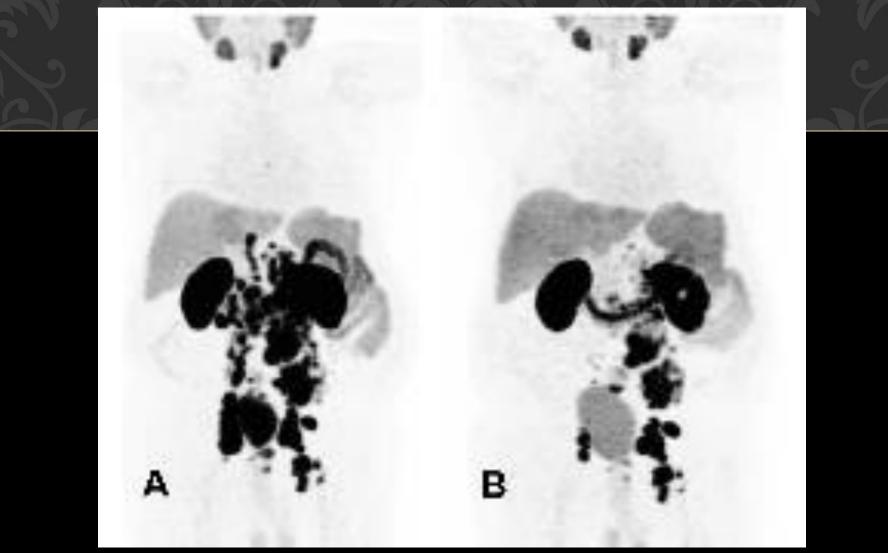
A 74-year old patient with hormone and chemo-refractory prostate cancer underwent PSMA PET/CT. (A) : which showed diffuse abdominal and iliacal lymph node metastases. The patient underwent RLT with 5.7 GBq 177Lu-PSMA. The PSA level was at the time of the therapy 790 ng/ml. (B): A partial response 7 weeks after RLT with 63% PSA decline at this time, the PSA level was 293 ng/ml
